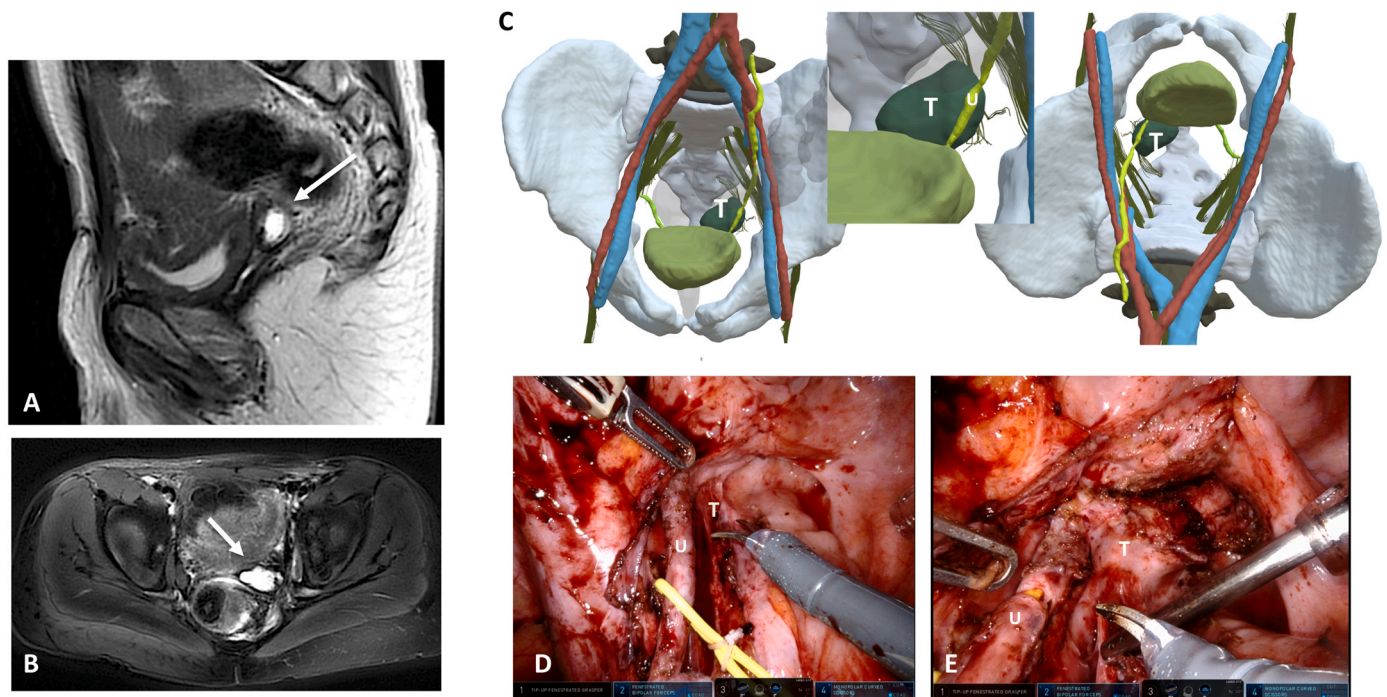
Recurrence of a pelvic rhabdomyosarcoma in a 4-year-old boy shown on preoperative MRI: sagittal (A) and axial (B) views (arrows). C: 3D model showing the left ureter (U) running onto the tumor (T). D: Intraoperative view of the dissection of the left ureter (U) from the tumor (T). E: The tumor (T) is almost resected.
